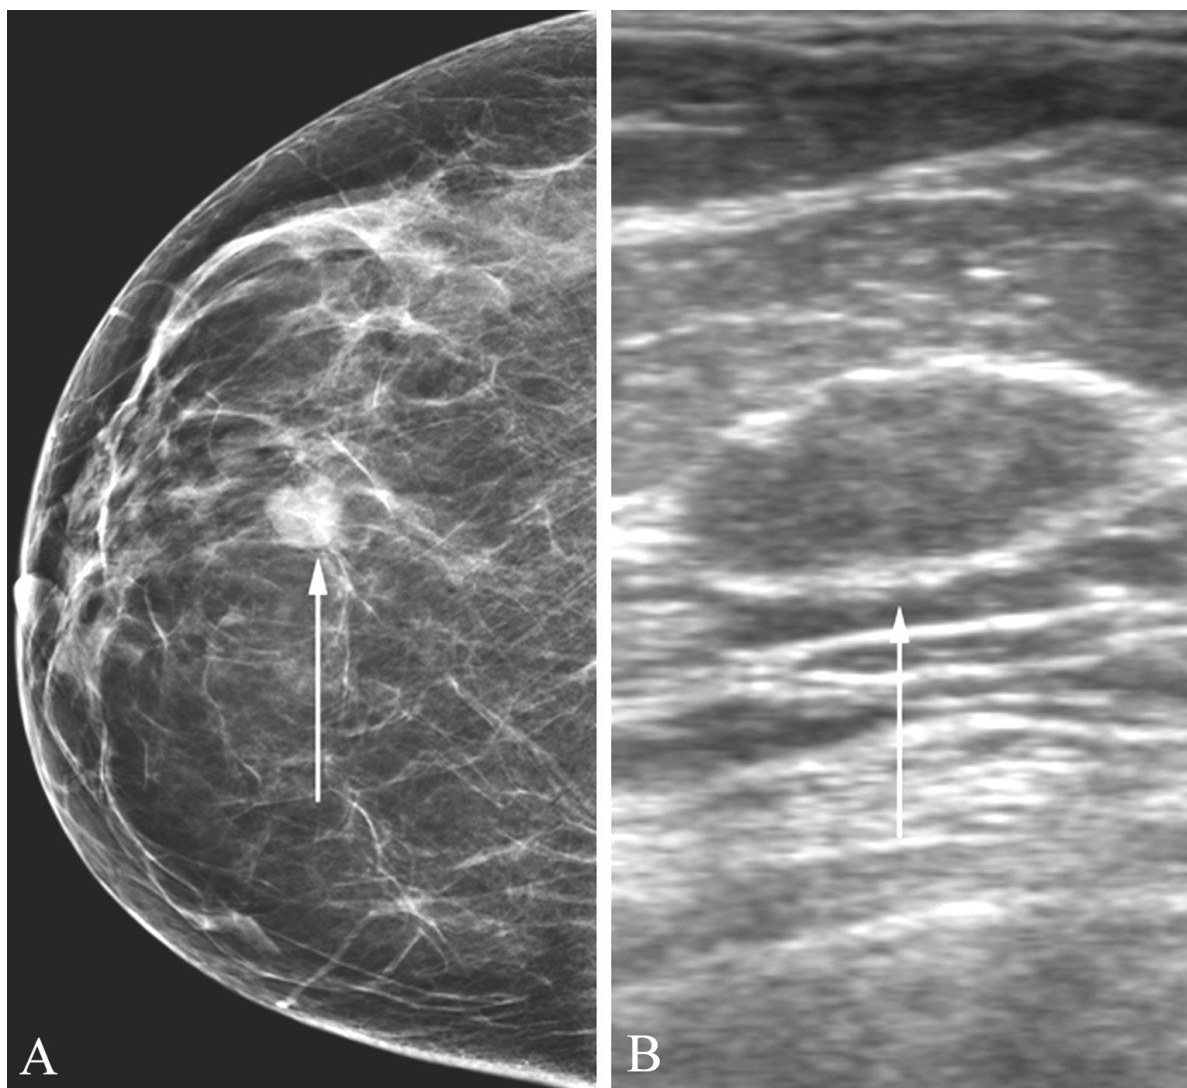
Fibroadenoma in a 48 year old woman with an abnormal screening mammogram, with ultrasound demonstrating a solid, benign appearing lesion at the location of the abnormality. A. Screening mammogram shows a circumscribed isodense mass (arrow) in the right breast. B. Breast ultrasound (with a different magnification) shows an oblong, sharply marginated, isodense solid mass without shadowing (arrow), characteristic of a fibroadenoma. The patient wanted the lesion removed despite its benign appearance, and pathology confirmed a fibroadenoma.
